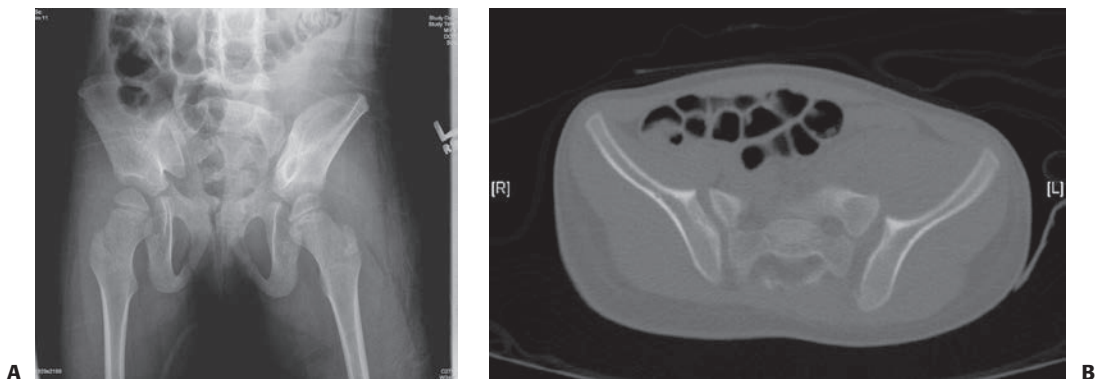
A 4-year old with a pelvic fracture primarily with posterior involvement. A: Pelvic outlet radiograph showing a posterior injury at the sacroiliac joint. B: CT scan showing the minimal posterior SI widening.
